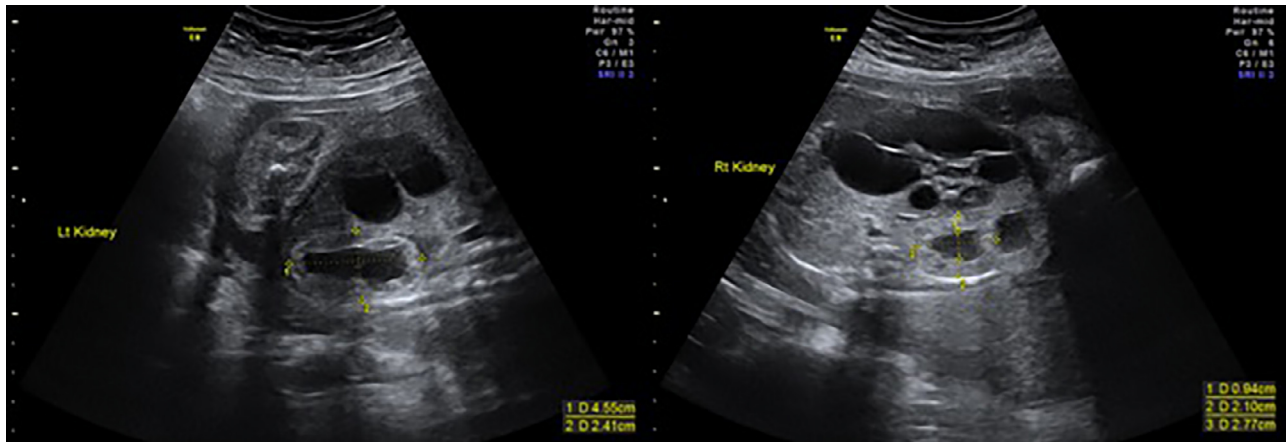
(a) Antenatal ultrasound at 28 weeks gestation showing left hydronephrosis. (b) Antenatal ultrasound at 28 weeks gestation showing right hydronephrosis.
